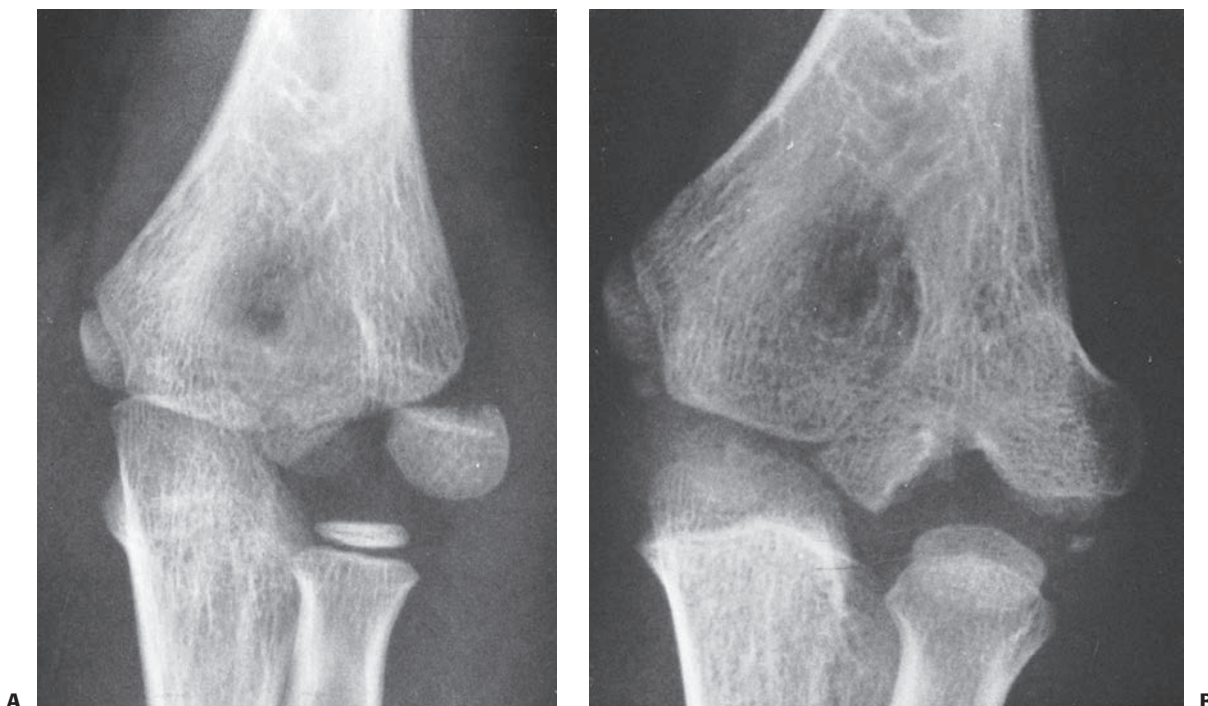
A: Injury film of a 7-year old who sustained a fracture of the capitellum that spared the trochlea and was treated with cast immobilization alone. B: Radiograph taken 2 years later showed complete fusion of the condylar epiphysis to the metaphysis, with the development of a “bifid” condyle.
